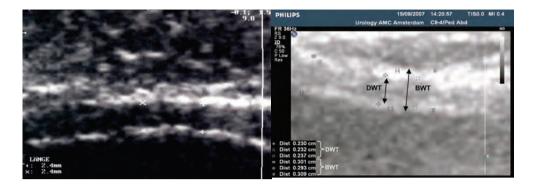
(a) Imaging of the anterior bladder wall with a linear 7.5 MHz ultrasound array, enlargement factor of the image 9.8fold. The outer and inner hyperechogenic (white) lines represent the adventitia and mucosa/submucosal tissue, respectively. The hypoechogenic (black) bar in between the hyperechogenic lines represents the detrusor. The measurement markers are positioned at the outer and inner border of the detrusor and indicate detrusor wall thickness (2.4 mm). (b) Measurement of detrusor wall thickness (DWT) and bladder wall thickness (BWT) in the same patient, enlargement factor of the ultrasound image 8fold. For DWT measurement it is necessary to measure the full distance of the hypoechogenic detrusor and for BWT measurement it is necessary to measure distance from the outer border of the hyperechogenic mucosa until the outer border of the hyperechogenic adventitia. BWT values in the same patient and bladder filling are always greater than DWT values; see measurement values on the left bottom.
